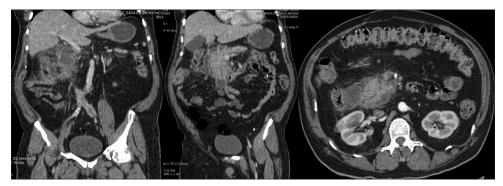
The head of pancreas is bulky with moderate peripancreatic fat stranding, multiple heterogeneous attenuating peripancreatic, and paraduodenal areas with focal internal fat attenuation—suggestive of acute focal pancreatitis with multiple peripancreatic and paraduodenal necrotic collections. There was no evidence of ascites or vascular complications. The modified computed tomography severity index was four
